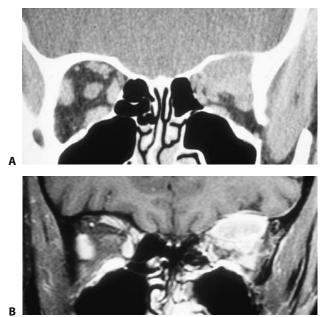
Images of left orbital metastasis from breast carcinoma. The infiltrative lesion produces bone destruction. (A) Contrast-enhanced coronal CT. Bone destruction is well identified as discontinuity of the cortical bone. (B) Contrast-enhanced coronal T1-weighted image. Bone destruction is suggested by discontinuity of the signal void of cortical bone. Meningeal neoplastic infiltration not seen on CT was identified on postcontrast MR scans.
